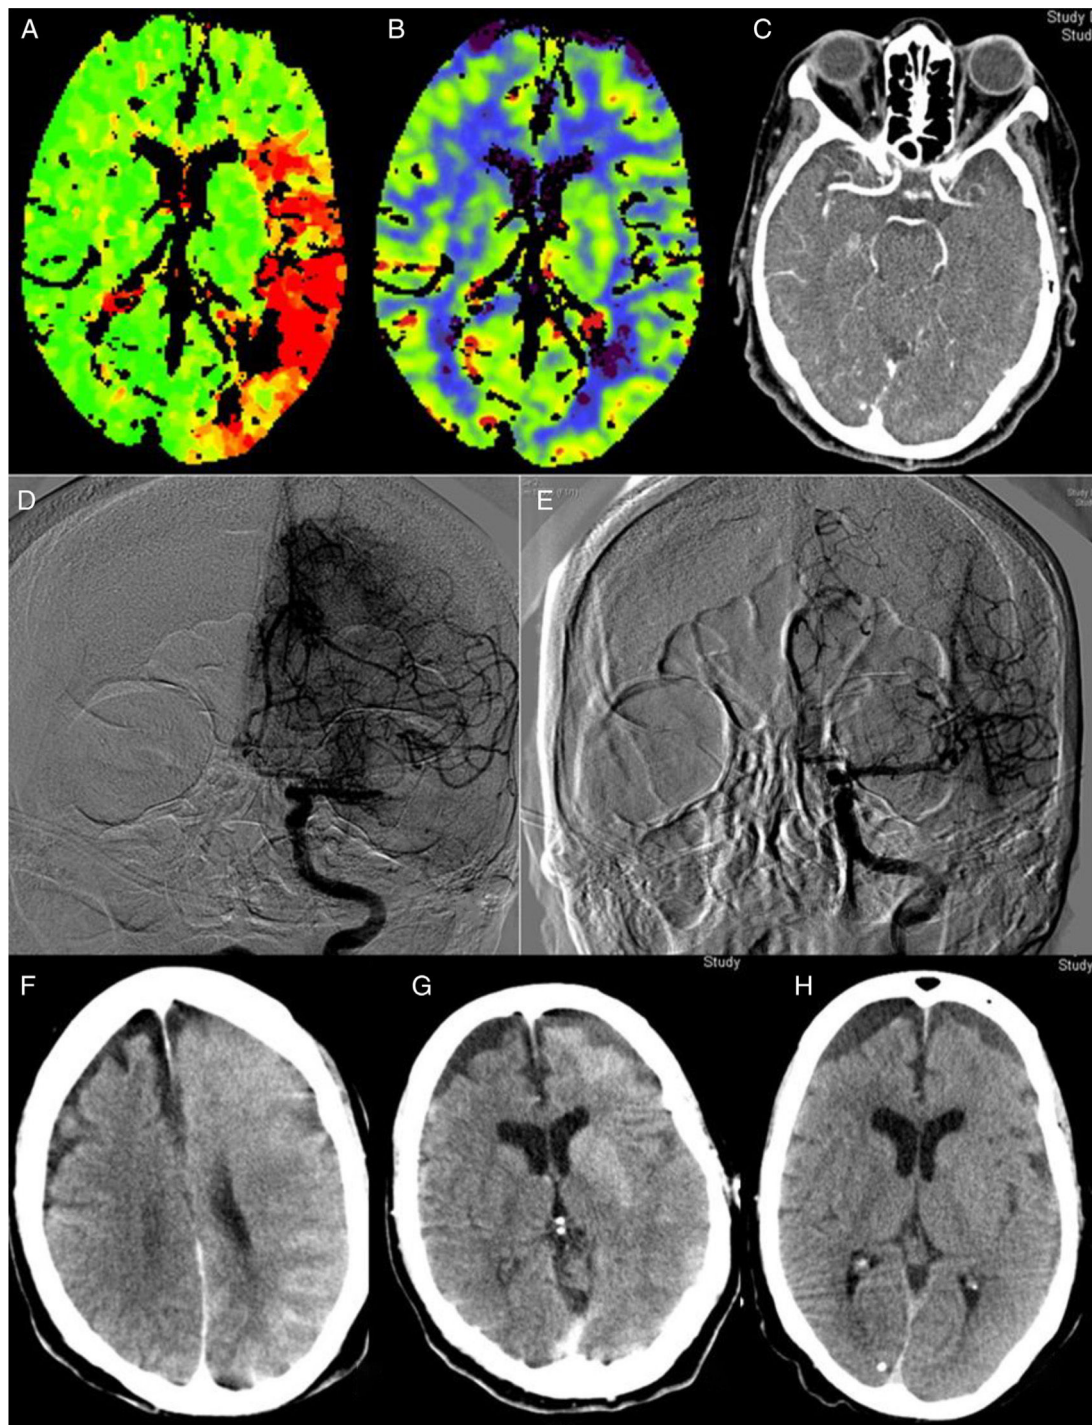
Perfusion CT (A and B): increased time to peak (A) in an extensive area of the left MCA territory, with no established ischaemia on the cerebral blood volume map (B). CT angiography (C): occlusion at the left proximal M1 segment. Angiography: occlusion at the left proximal M1 segment (D) with complete recanalisation after one pass of a Penumbra Ace[®] distal aspiration catheter (E). CT scan after thrombectomy (F and G): generalised contrast extravasation in the left hemisphere. CT scan at 24 hours (H): signs of oedema in the left hemisphere with disappearance of the accumulated contrast and no signs of established ischaemia.
